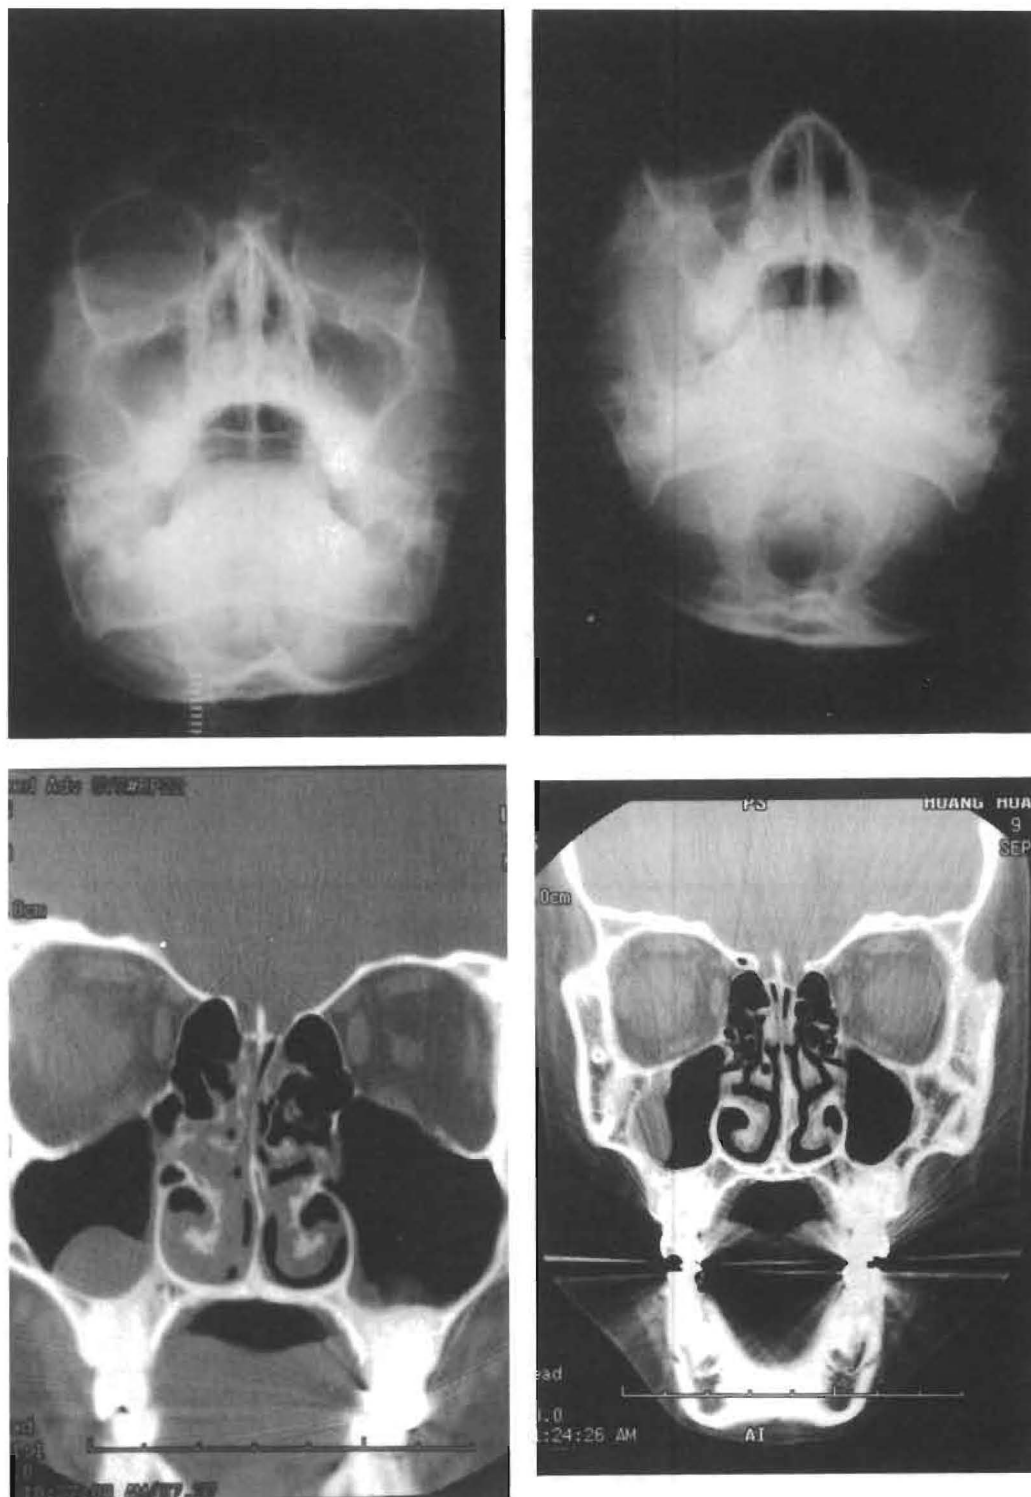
Waters' view of a 14-year-old boy (A) and a 9-year-old boy (B) show partial opacification of right maxillary sinus in these two patients. Representative CT scans show bilateral retention cyst (C) and right retention cyst (D).
